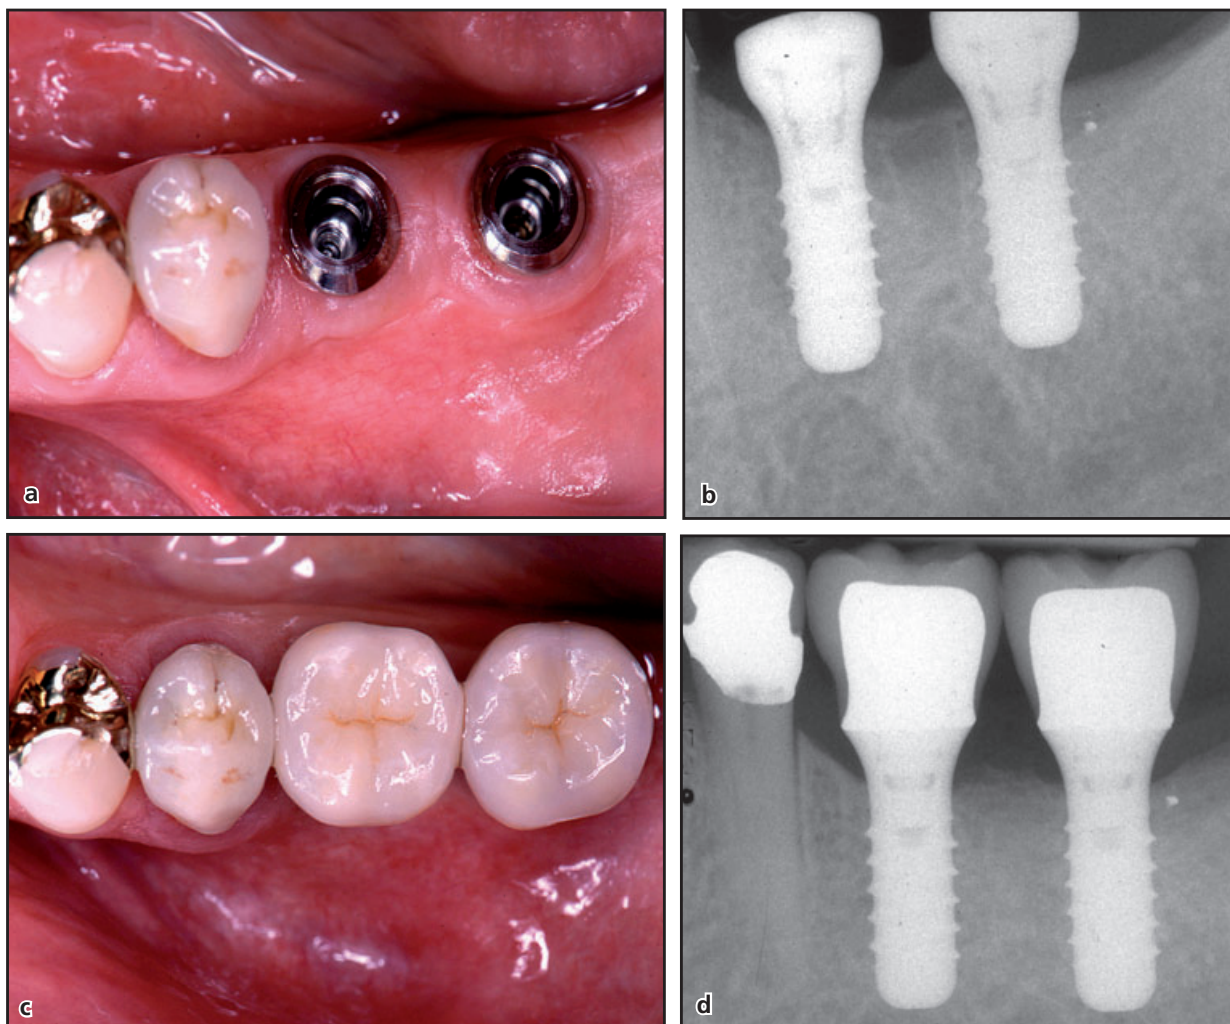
Increasing subjective chewing comfort by replacing missing molars in a mandibular free-end situation. (a) Installation of two standard (4.1 mm diameter) Straumann® implants (8 mm), 6 and 14 mm distal to the distal aspect of tooth 35. (b) Radiographic view at the time of implant installation. (c) Two molar crowns on implants in position 36 and 37, 8 years after installation. (d) Radiographic view, 8 years after loading of the implants.
